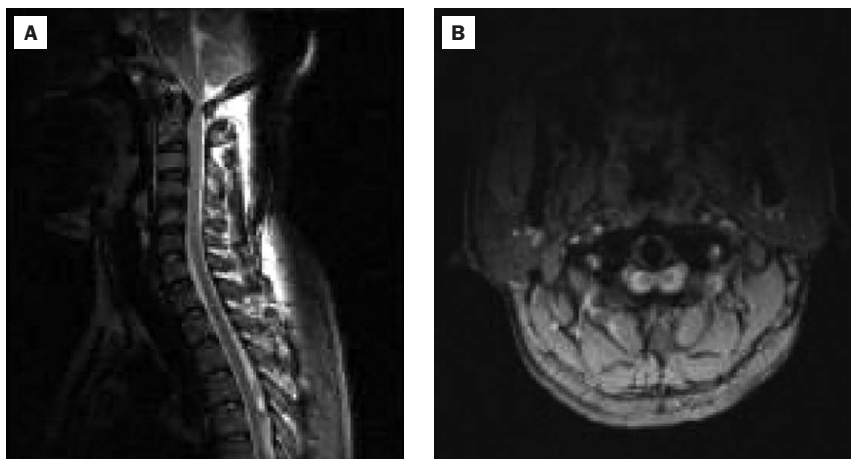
Cervical spinal magnetic resonance imaging reveals stenosis at the atlas level. The axial cut is at the C1 level. The sagittal canal diameter is 12.40 mm and the sagittal dural sac diameter is 6.23 mm at the C1 level. Note the high signal intensity change in the posterior aspect of the cord at the C1 level in the sagittal view, which may indicate compressive myelopathy.
